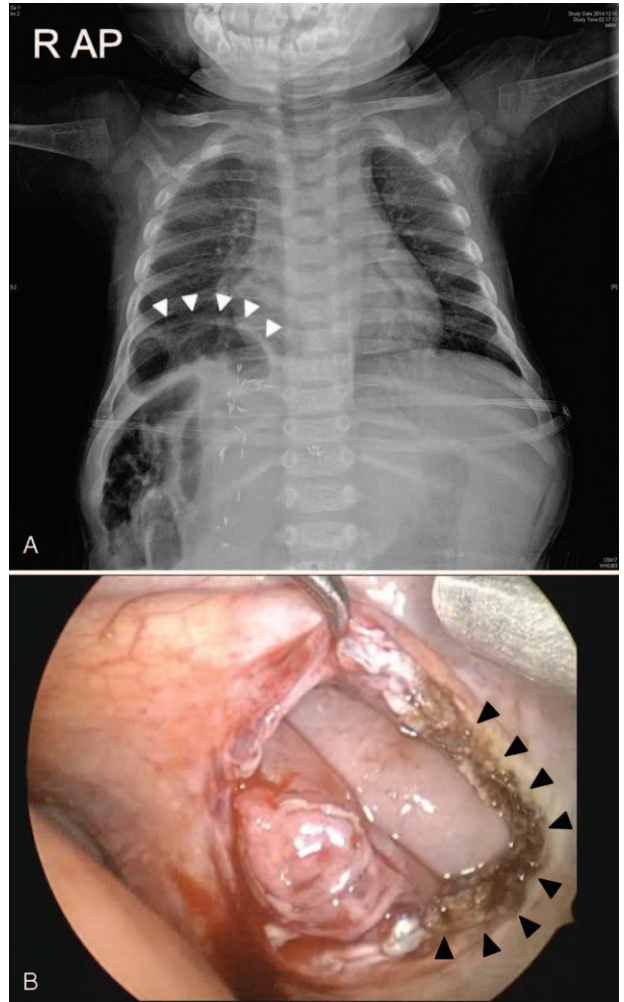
(A) Chest X-ray showing an upward bulging air density (white arrows) through the right diaphragm and (B) thoracoscopic view of the right diaphragmatic defect after reduction of the herniated small intestine in Case 2. Black arrows indicate the laterally extended portion of the diaphragmatic defect.
